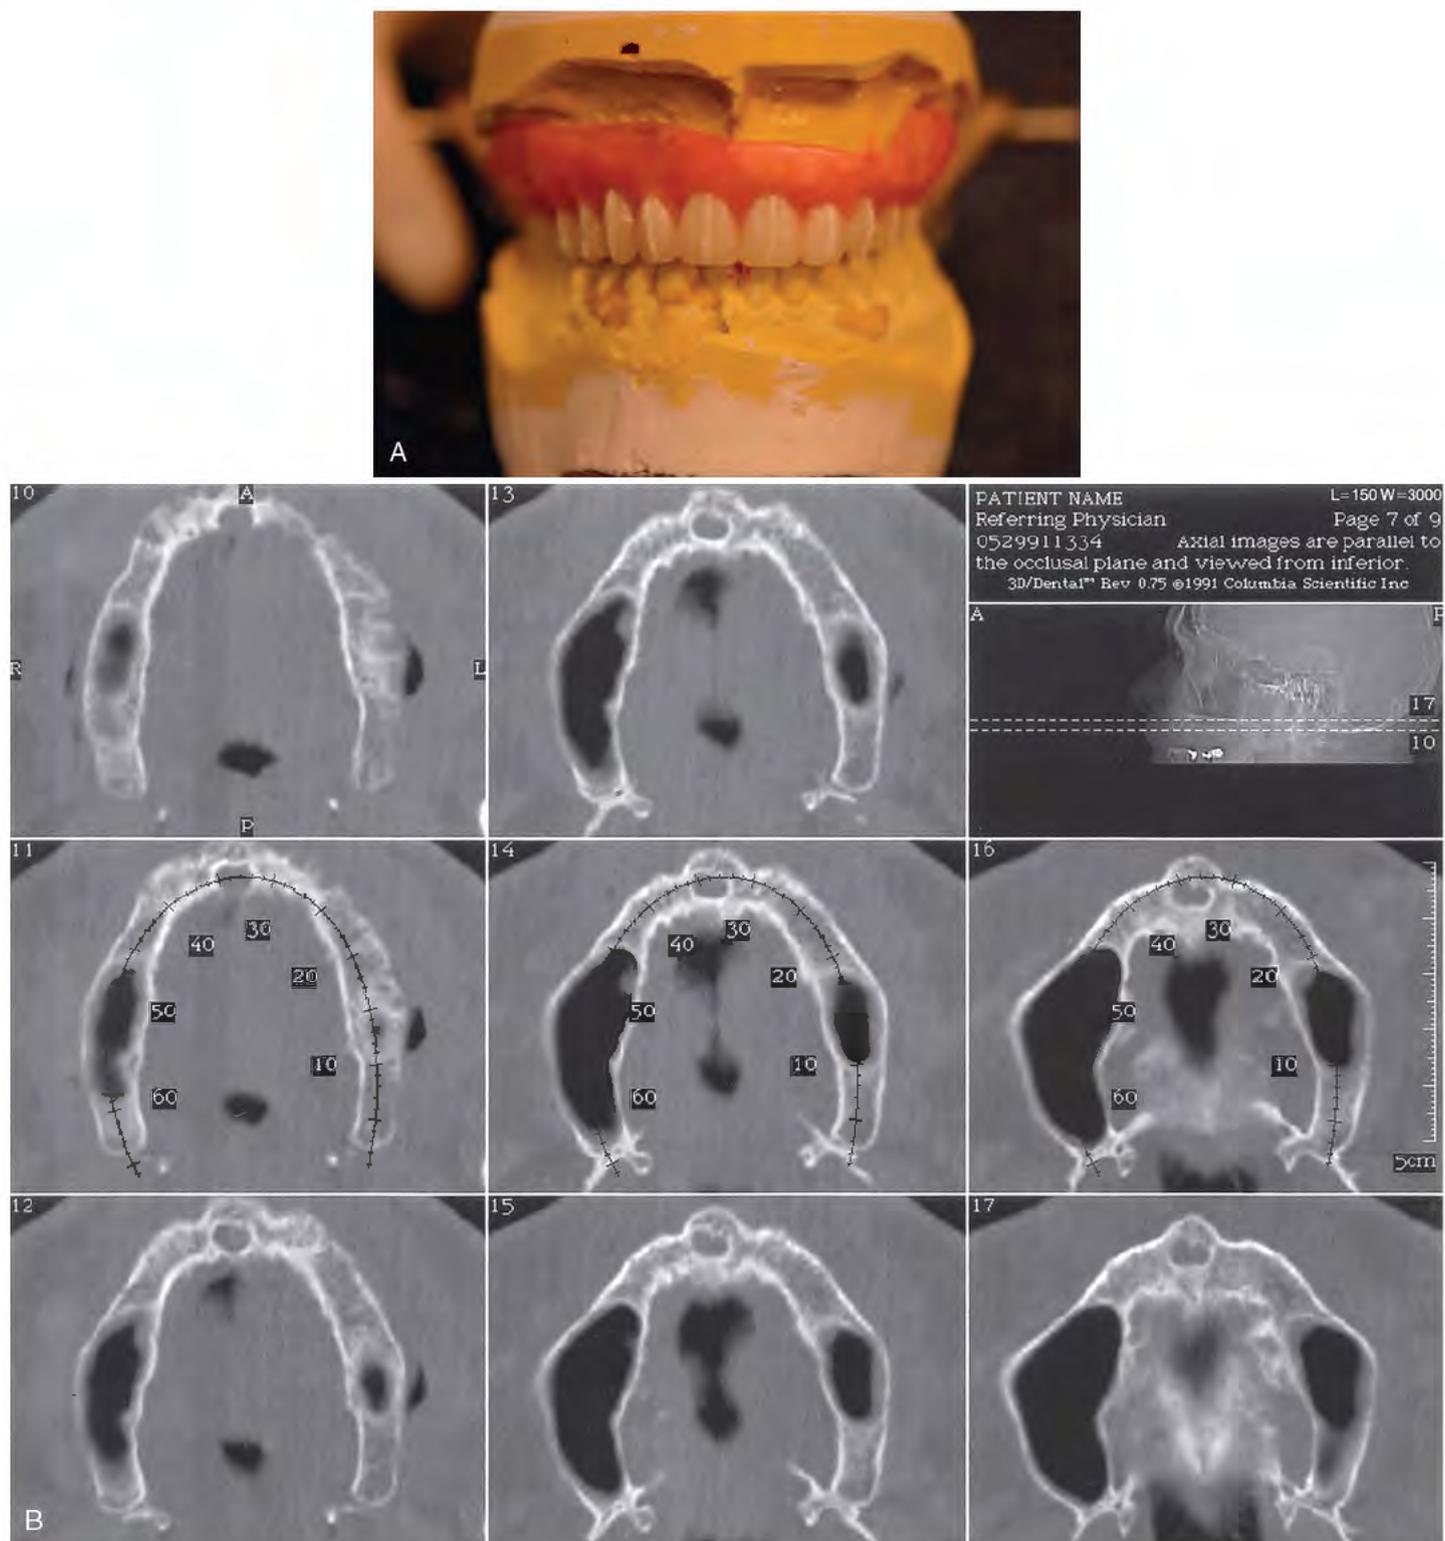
A, Diagnostic waxup of a full denture with vertical radiopaque markers for radiographic identification of implant sites. B, Transaxial (occlusal) views are used for the maxilla as well as the mandible. These eight images, numbered 10 through 17, offer dramatic representations of this geometrically complex structure at evenly spaced intervals (1.5 mm apart). The image at the upper right, marked *A*, known as a *scout film*, presents the inferior to superior perimeters of the numbered images.
